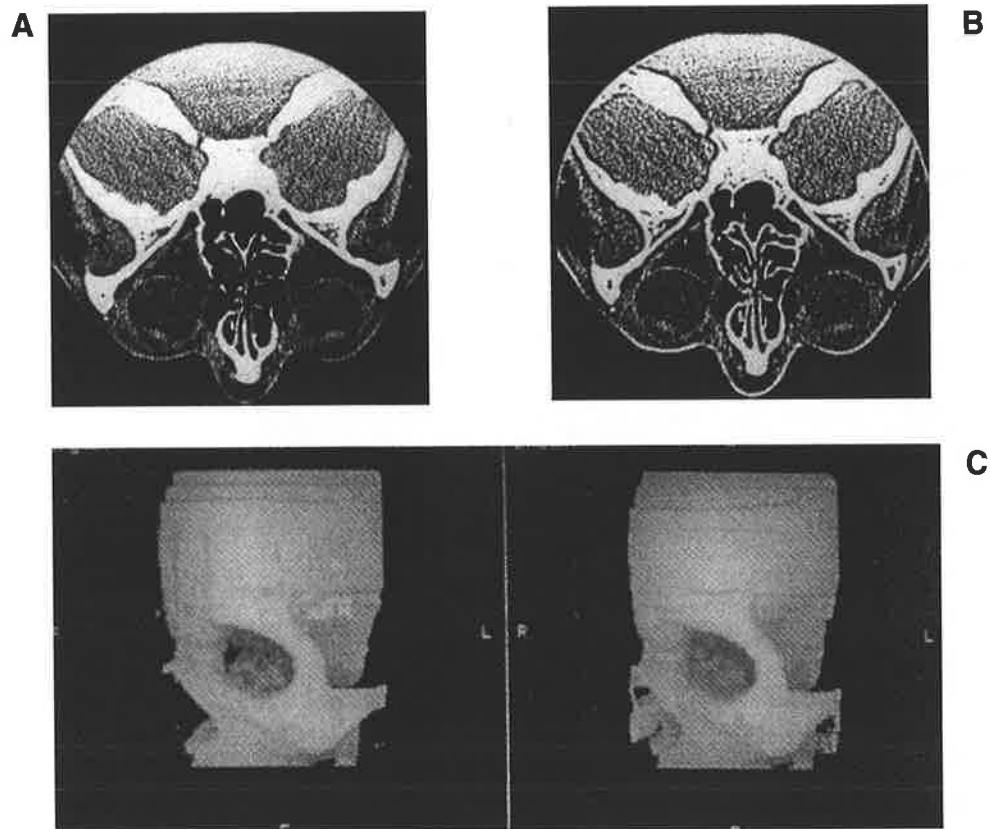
Use of combined linear and nonlinear filtering to improve detection of papyraceous ethmoid bone. A. Original CT slice. B. Filtered CT slice. C. Three-dimensional images before (left) and after (right) filtering to reduce "pseudo-foramina".
